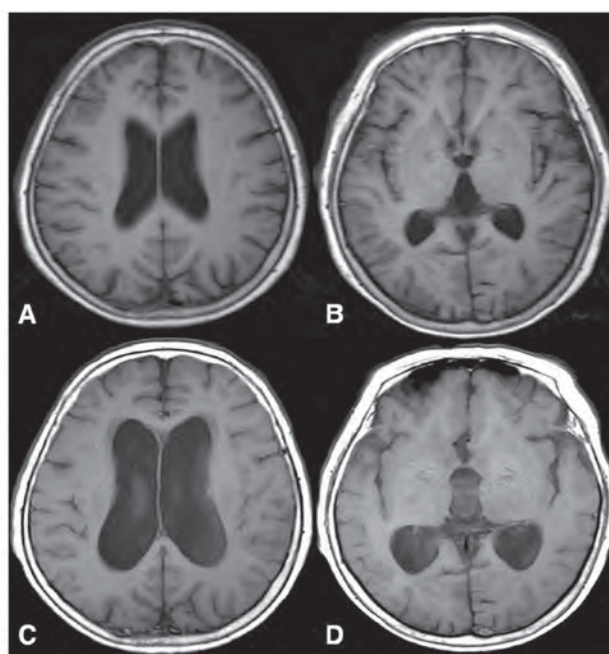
T1-weighted axial brain MRI showed increased volume of lateral and 3rd ventricles, suggestive of obstructive hydrocephalus. (A & B: at the time of diagnosis, C & D: aggravated state)
